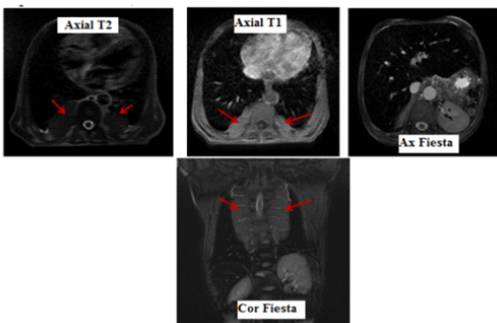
36 year old male patient who is a known case of Thalassemia with history of repeated blood transfusions (Splenectomized), MR images shows extramedullary hematopoiesis.
